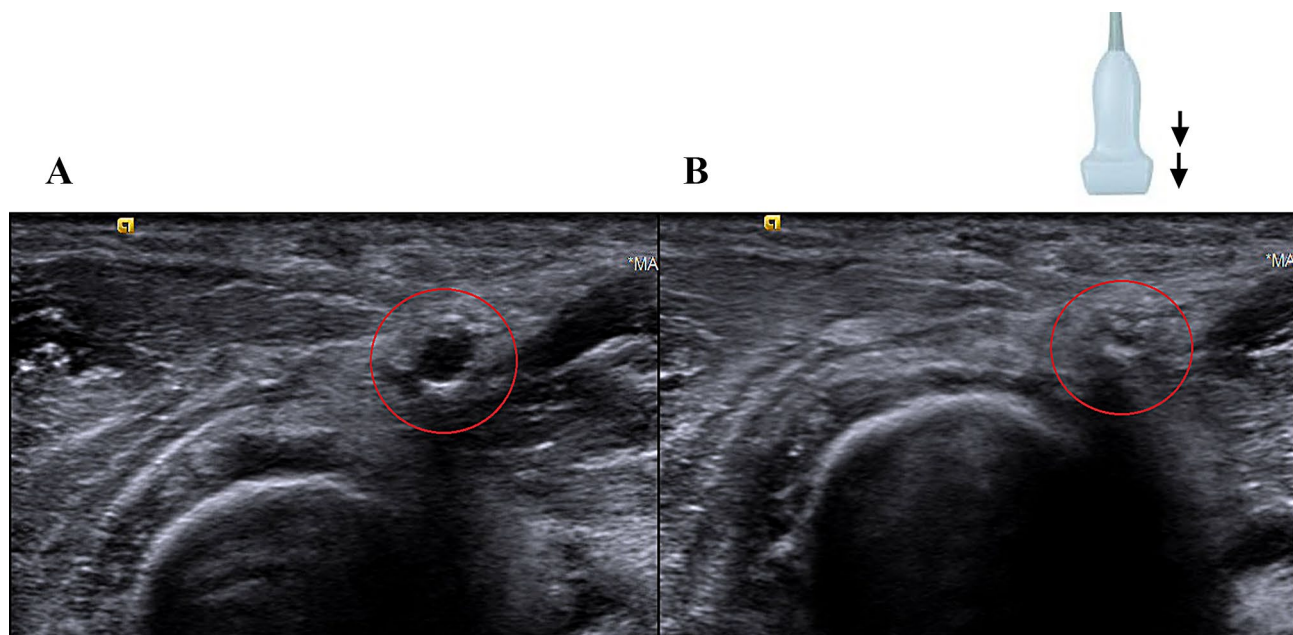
Assessing compressibility of the artery: a calcified artery (panel a) is compressible, when pressed against the bone by the ultrasound probe (panel b). See also Supplementary Videos [S1](#) and [S2](#)
